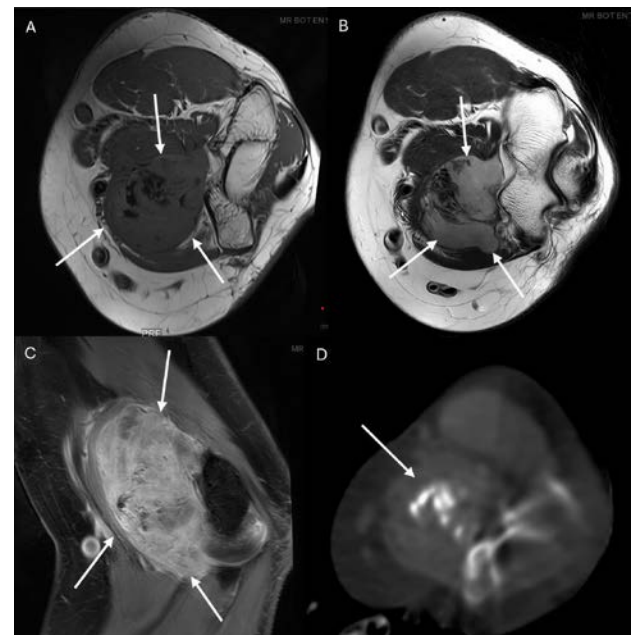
Axial T1-weighted image (A) demonstrates a heterogeneous soft-tissue mass with predominantly intermediate signal intensity relative to muscle (arrows). On the T2-weighted image (B), the lesion appears markedly heterogeneous with predominantly high to intermediate signal intensity and intralesional areas of lower signal. Post-contrast Dixon T1-weighted image (C) shows heterogeneous and predominantly solid enhancement with irregular margins. Axial CT image demonstrates internal calcifications within the soft-tissue mass (D, arrows). In contrast to TSGCT, the lesion demonstrates predominantly high T2 signal, lacks a clear synovial-based growth pattern, and contains internal calcifications on CT, a feature highly atypical for TSGCT and more suggestive of synovial sarcoma.
